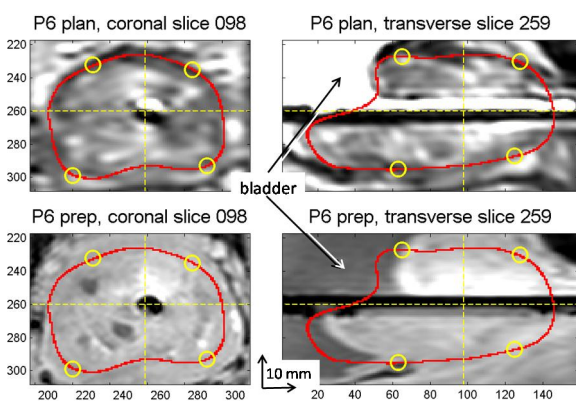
T2-weighted planning image for P6 in top graphs and T1-weighted preparation image in bottom graphs. Bladder is marked with arrows and prostate boundary against bladder has moved in between images in top and bottom graphs.
